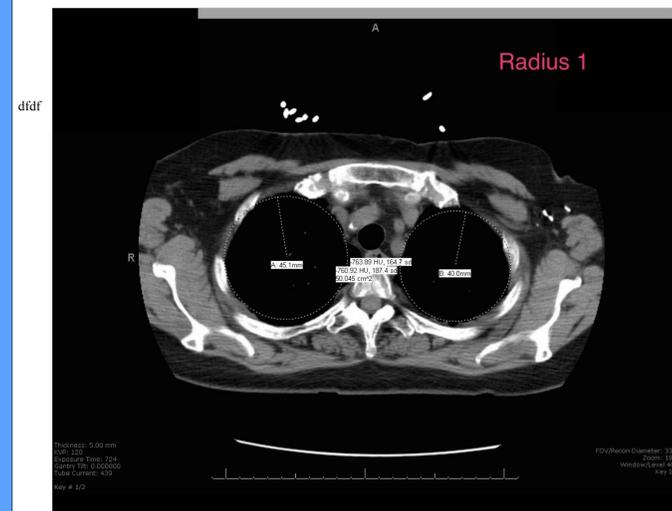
CT CHEST, first radius
